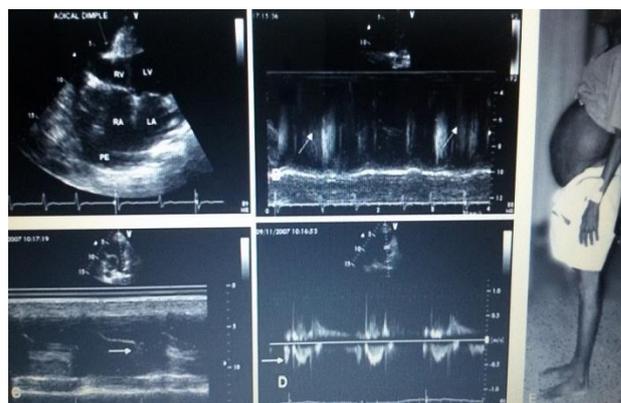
The clinical and echocardiographic features of right ventricular endomyocardial fibrosis. Clinical picture (E) shows the massive ascites with no pedal oedema. Echo pictures A to D show: A. apical 4 chamber view showing the fibrotic obliteration.
